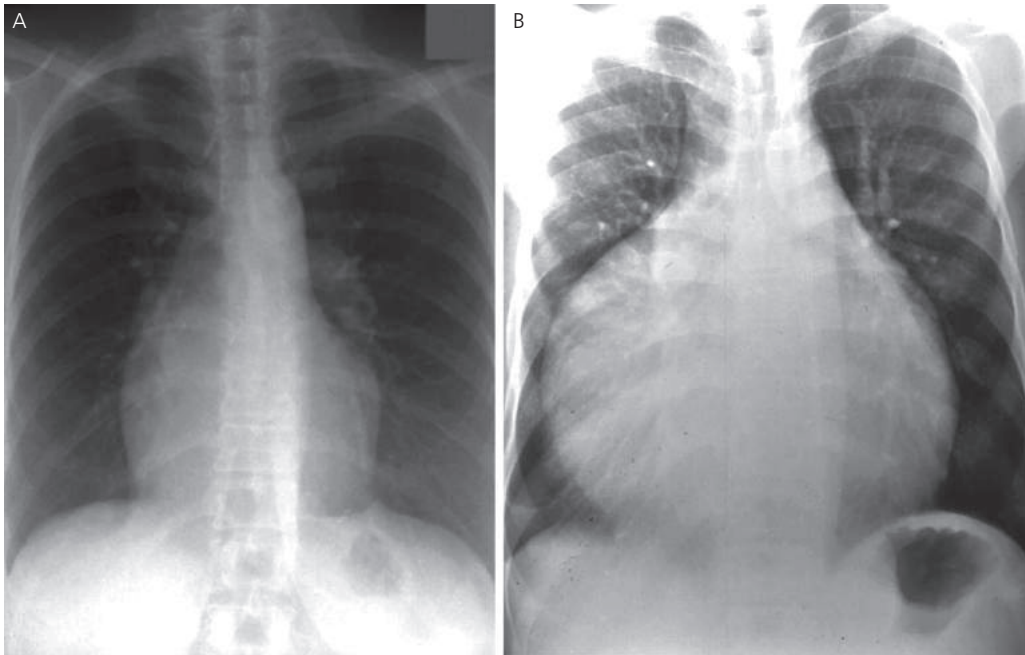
Chest X-rays in L-TGA.
